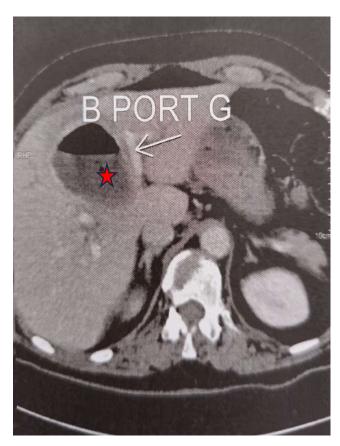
CT scan showing an 8 cm hydatic cyst (red star) with air bubbles inside.
